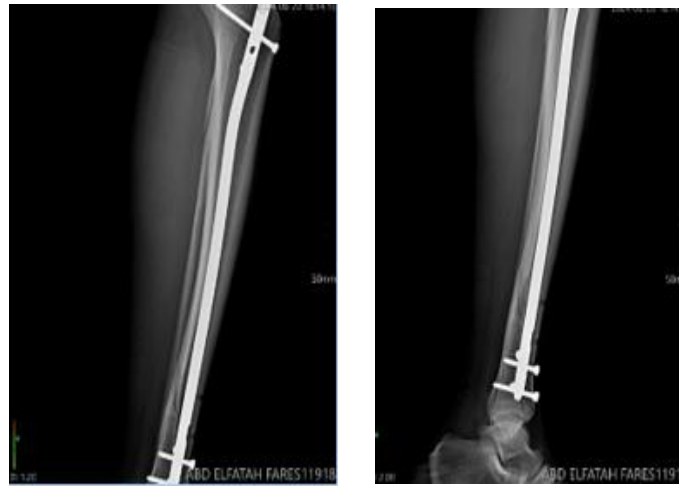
post-operative X-rays for the first case; anterior and lateral views
